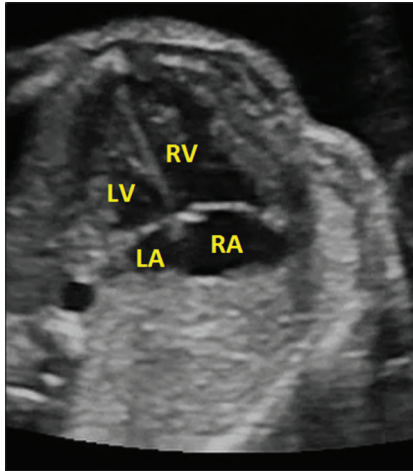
Apical four-chamber view shows the right ventricular hypertrophy and enlargement
